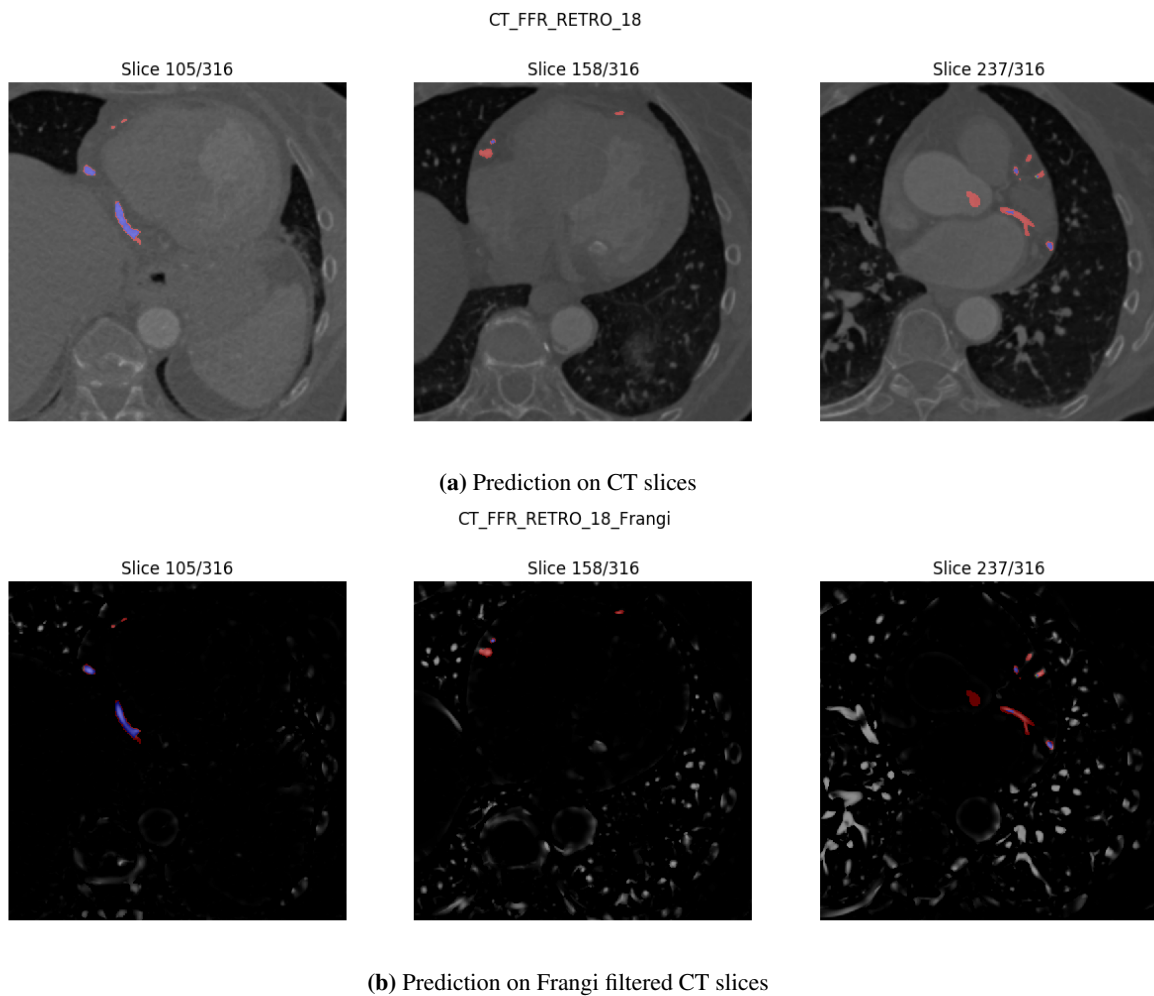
A selection of some of the CT and Frangi filtered CT slices of the BVNet model's worst prediction of the coronary artery splits with combined CT and Frangi filtered CT images as input, where the corresponding prediction is overlaid. The prediction is color-coded with blue=TP, green=FP, and red with low opacity=FN.
